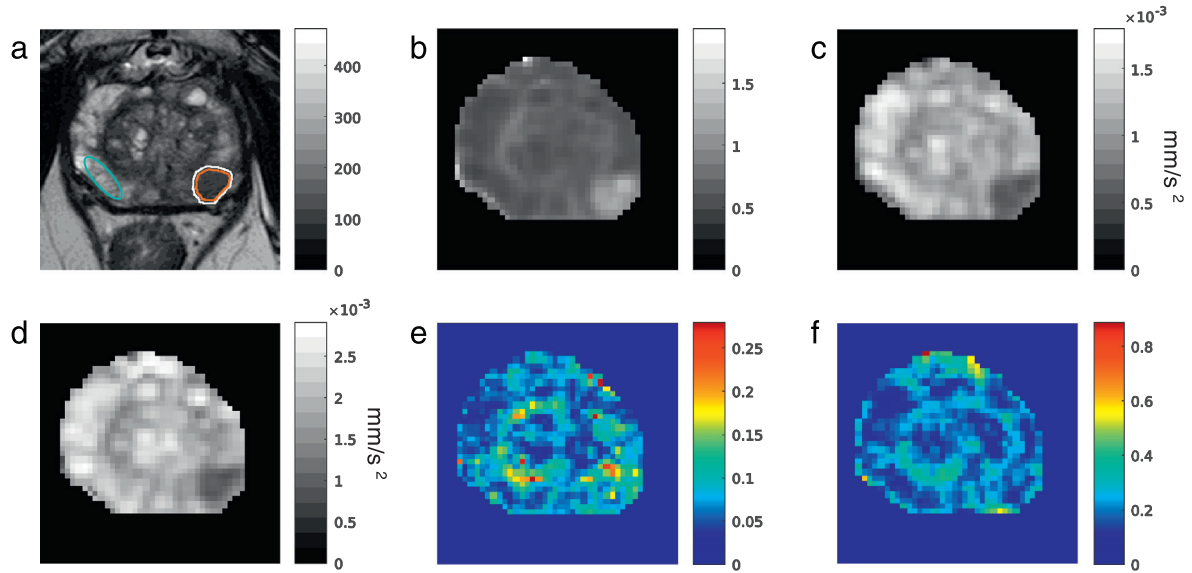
Diffusion parametric maps. T2-weighted image (a) with outlined PCa (orange), PT (white), and benign ROIs (light blue). The presence and the extension of malignant tissue (subject with a GG3 lesion) is clearly visible in K-, MD-, and D map (b, c, and d, respectively). FA map (f) shows no contrast between PCa and benign tissue, while in KFA map (e) PCa appears slightly more intense than benign tissue; however, it is not sufficient to correctly individuate PCa region or PCa extension. (Color version of figure is available online.)
